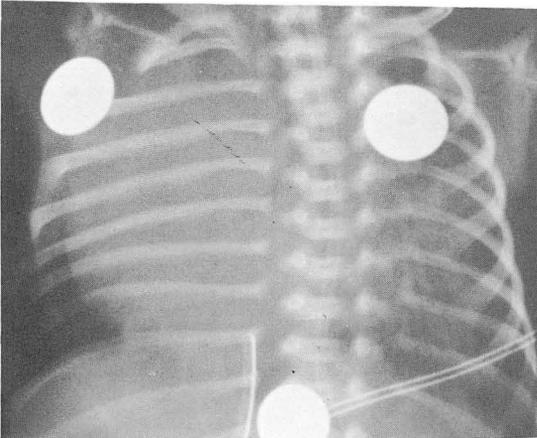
Case 1. a. Initial chest X-ray showed severe hyaline membrane disease appearance. b. Follow-up after 2 months, demonstrated perihilar streaky density and hyperaeration.
